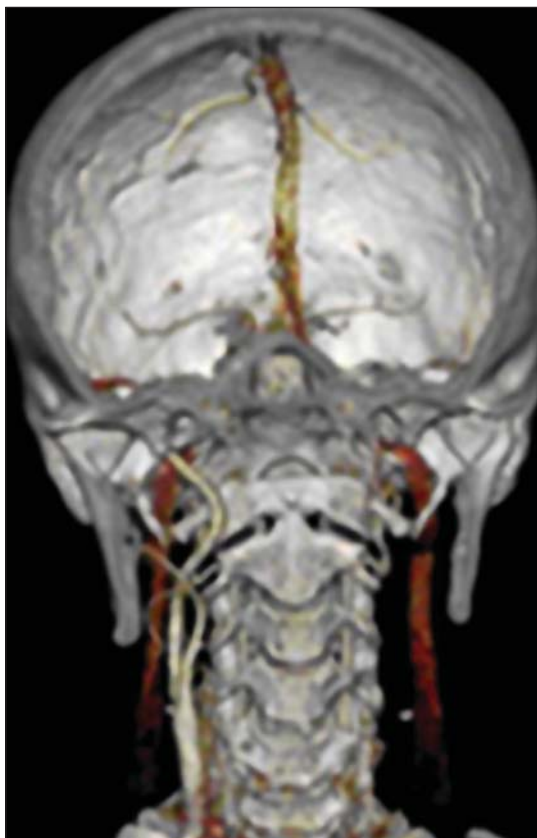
Patient MM-CT-A. Occlusion of the left CCA, ECA, and ICA.
